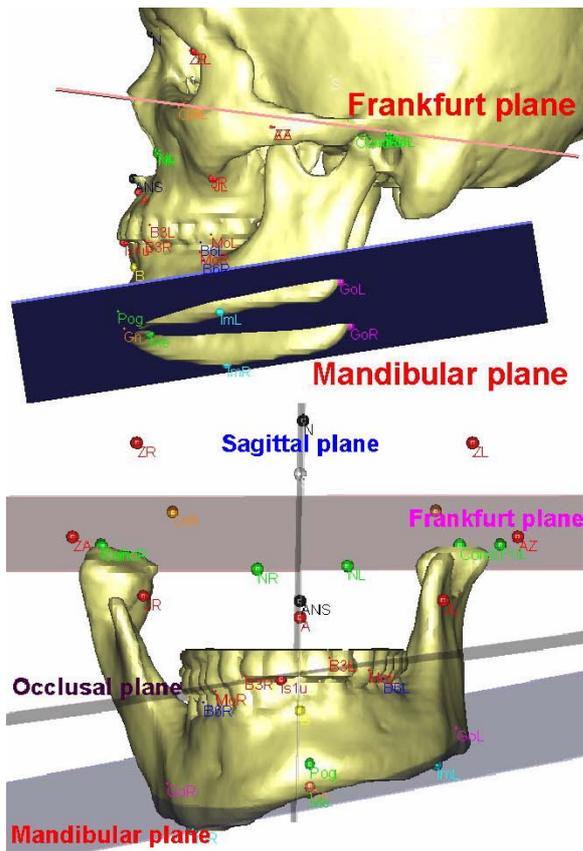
3D CT of patient with asymmetrical. Skeleton and dentition compared to the standard norms
